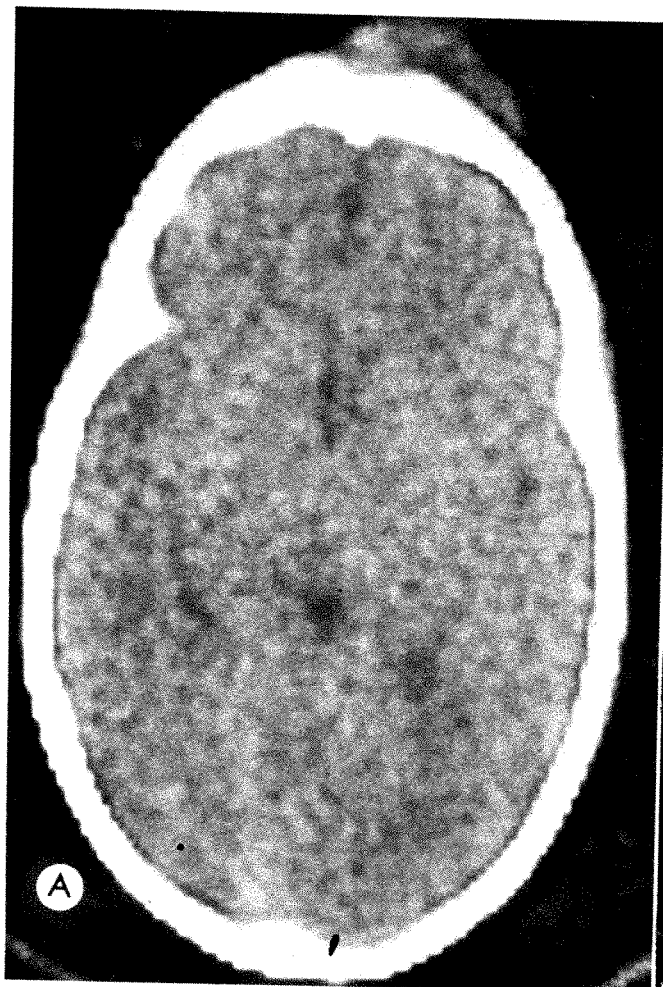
Subgaleal abscess secondary to osteomyelitis. 15-month-old boy with history of surgery for nasofrontal encephalocele and nasal glioma during newborn period. Patient developed right frontal fluctuant mass and fever; plain roentgenograms showed lytic area in frontal bone. A, CT scan showing crescentic region of soft tissue density projecting extracranially from right frontal bone. B, Scan after contrast showing enhancement of margin. Subsequently, pus drained from mass and infected bone graft removed.
